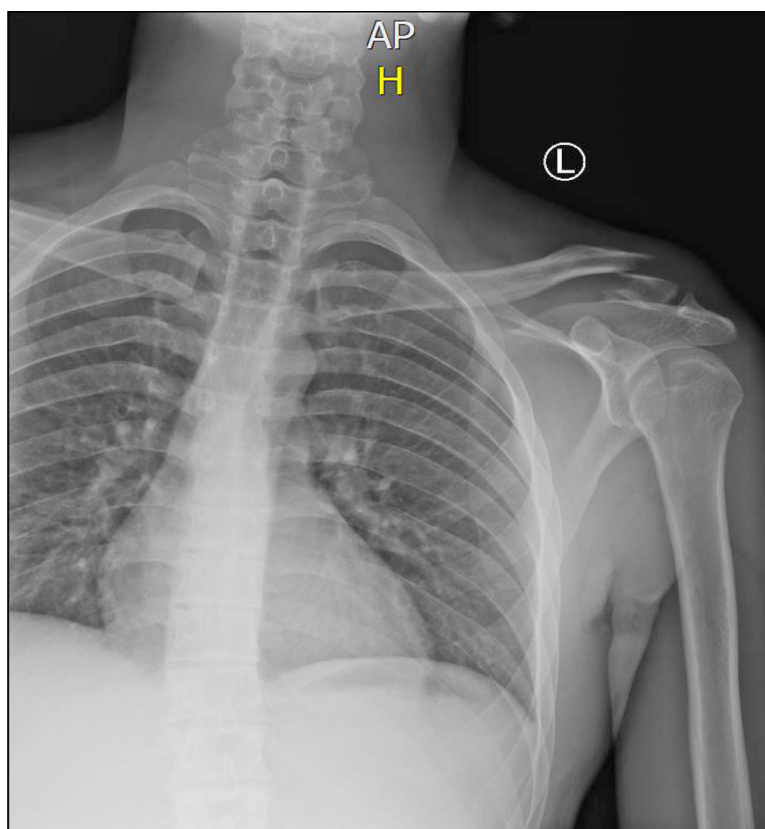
Preoperative anteroposterior radiograph of the left clavicle showing the distal fracture of left clavicle.
